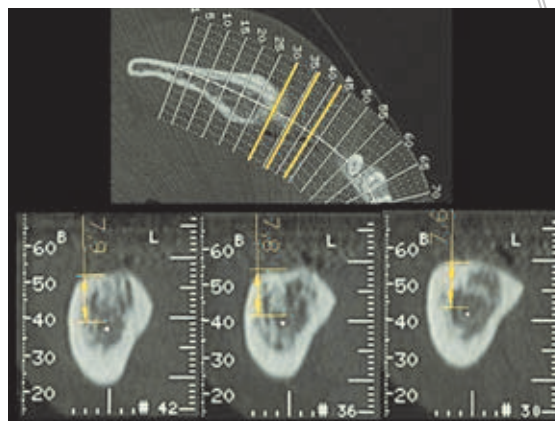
Preoperative dental computed tomography (CT) scans used to evaluate patient eligibility (6 to 8 mm of bone above the nerve canal) in the study.
